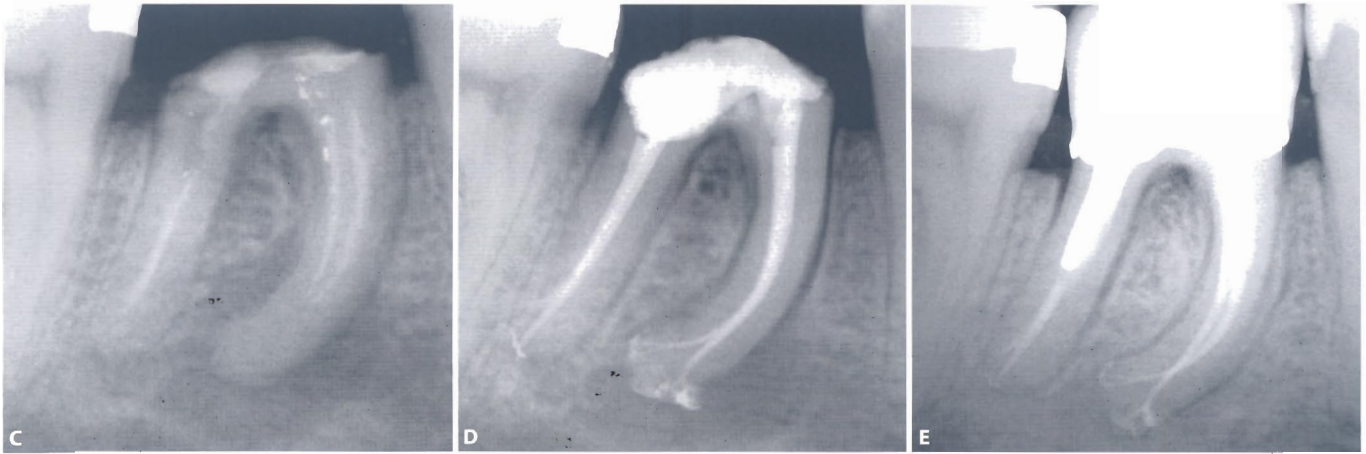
(Continued) C. Preoperative radiograph of the lower right first molar. D. Postoperative radiograph. E. Follow up radiograph at six months (G. Cantatore).
